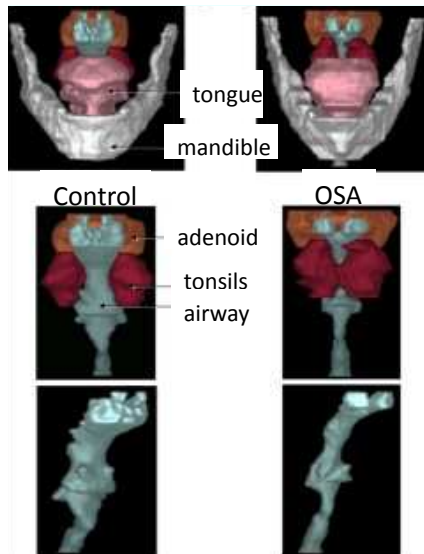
Surface rendering of AFC-segmented MRI. Left: Upper airway and other surrounding structures (mandible, adenoid, tonsils, tongue) of a normal child; Right: a child with OSA.
